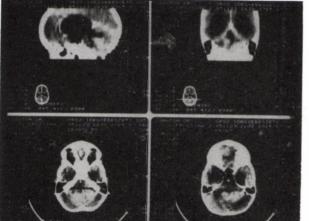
BAEPs and CT scan in a 2-year-old child with right cerebello-pontine astrocytoma
